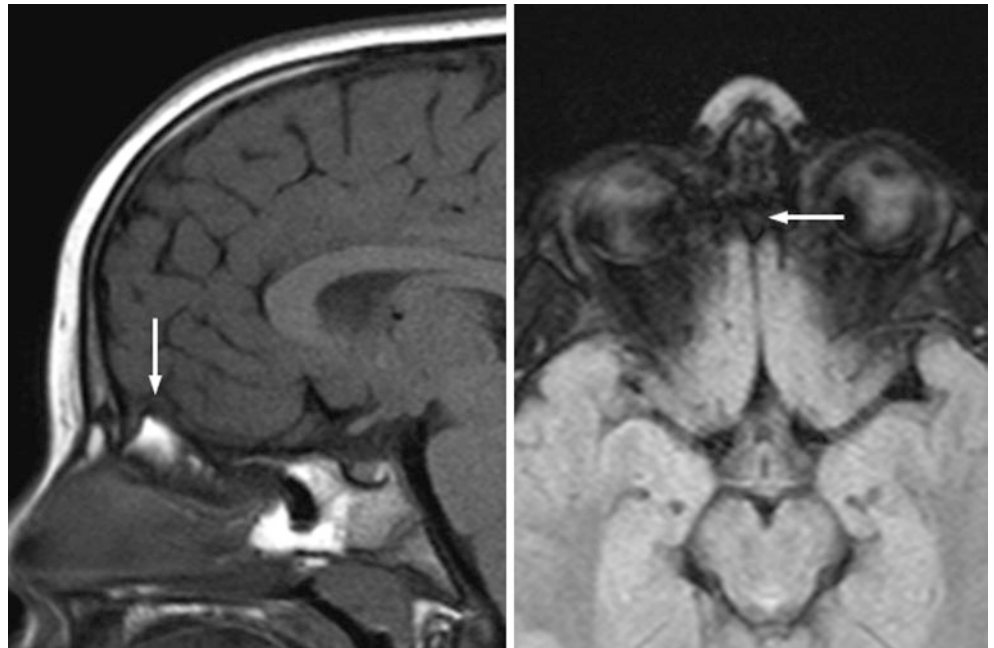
A 5 year old with a T1-bright crista galli (*left*) that suppresses (darkens) on FS FLAIR (*right*) owing to the presence of internal fatty marrow
